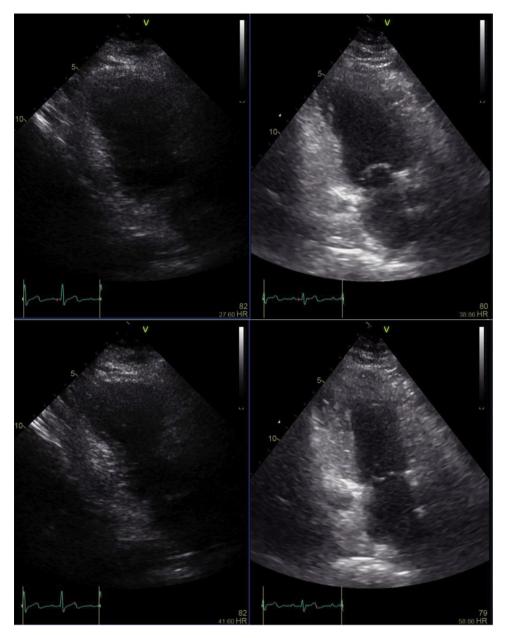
Two-chamber echocardiogram view demonstrating diastolic phase on admission on the top left and 4 months later on the top right. Two-chamber echocardiogram view demonstrating systolic phase on admission on the bottom left and 4 months later on the bottom right. Left ventricle basal hypokinesis and apical akinesis noted in the bottom left image.
